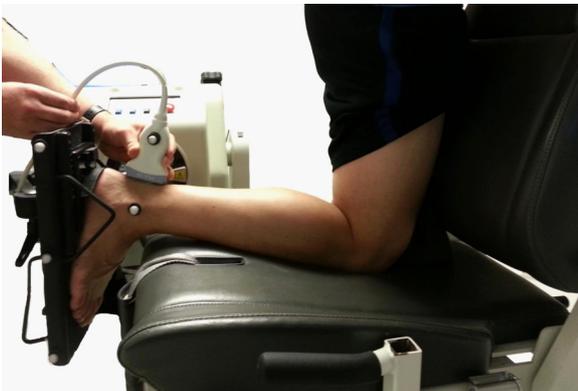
The setup for the collection of moment arm data. This is the same setup for the collection of the brightness and stress data with a change in probe position and/or orientation. Note the ankle and knee at 90° and markers placed on the malleoli and at the center of the ultrasound transducer.
